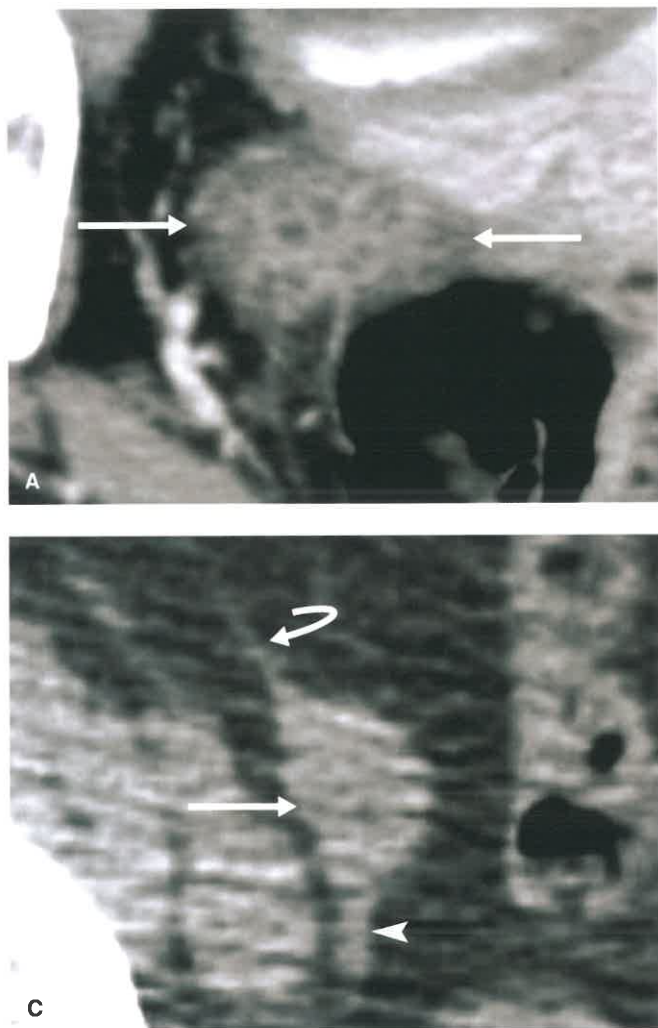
Normal Ovaries. A: Axial postcontrast CT image shows a normal ovary (between arrows) with follicles in a menstrual age woman. Follicles serve as an anatomic landmark to recognize the ovary. B: Coronal T2-weighted MR image of a 38-year-old woman shows the normal oval shape of the ovary (between arrowheads) marked by high signal intensity thin-walled follicles. C: Axial CT image of a postmenopausal woman shows the small oval soft tissue appearance of the normal postmenopausal ovary (straight arrow) without follicles. The identity of the ovary is confirmed by recognizing the suspensory ligament of the ovary (curved arrow) and the utero-ovarian ligament (arrowhead).
